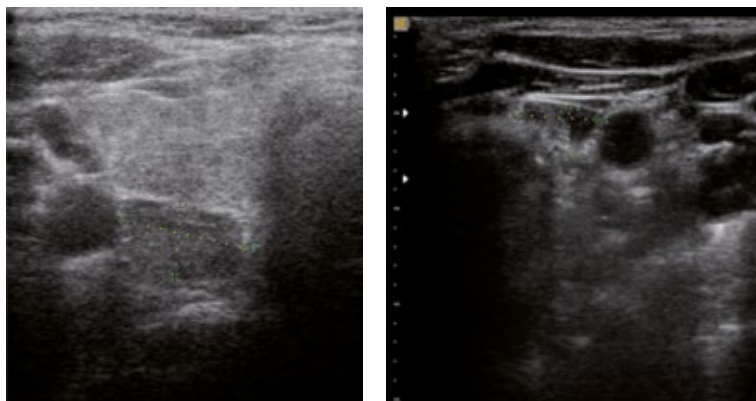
Adenomas of the upper (a) and lower (b) parathyroid glands on the ultrasound
